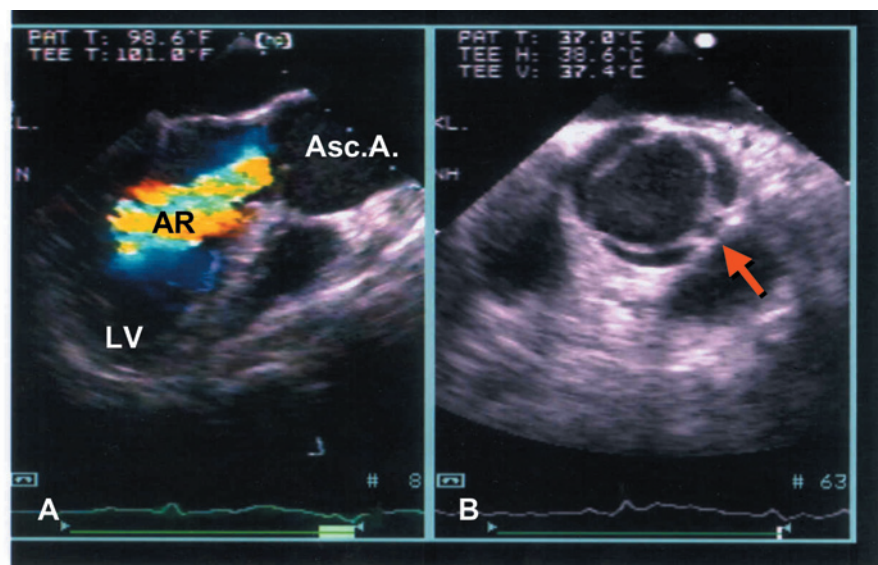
A, Transesophageal echocardiogram (longitudinal 2-chamber view) of insufficient bicuspid aortic valve. Asc.A indicates ascending aorta; AR, aortic regurgitation jet; LV, left ventricle. B, Transesophageal echocardiogram (cross section) of bicuspid aortic valve. Arrow indicates enlarged leaflet with the raphe.
